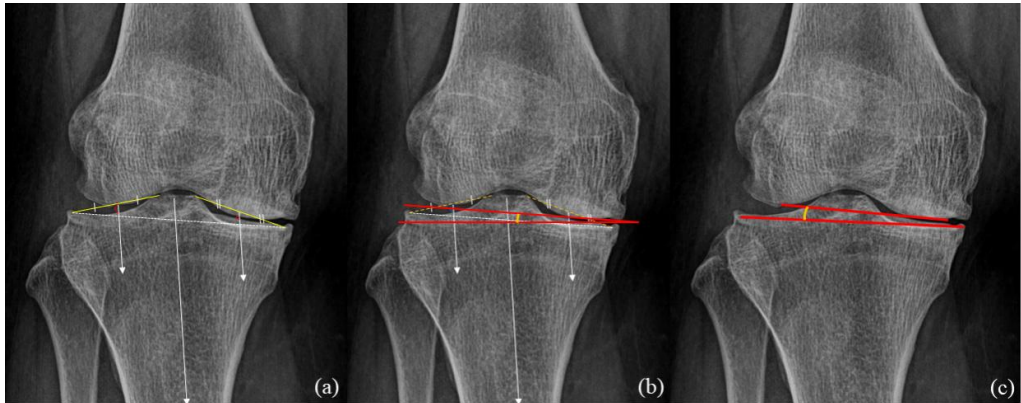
Knee joint standing radiograph. (a) MJW & LJW, (b) G-KJLO, (c) JLCA. G-KJLO: knee joint line orientation; JLCA: joint line congruency angle; LJW: lateral joint width; MJW: medial joint width.
